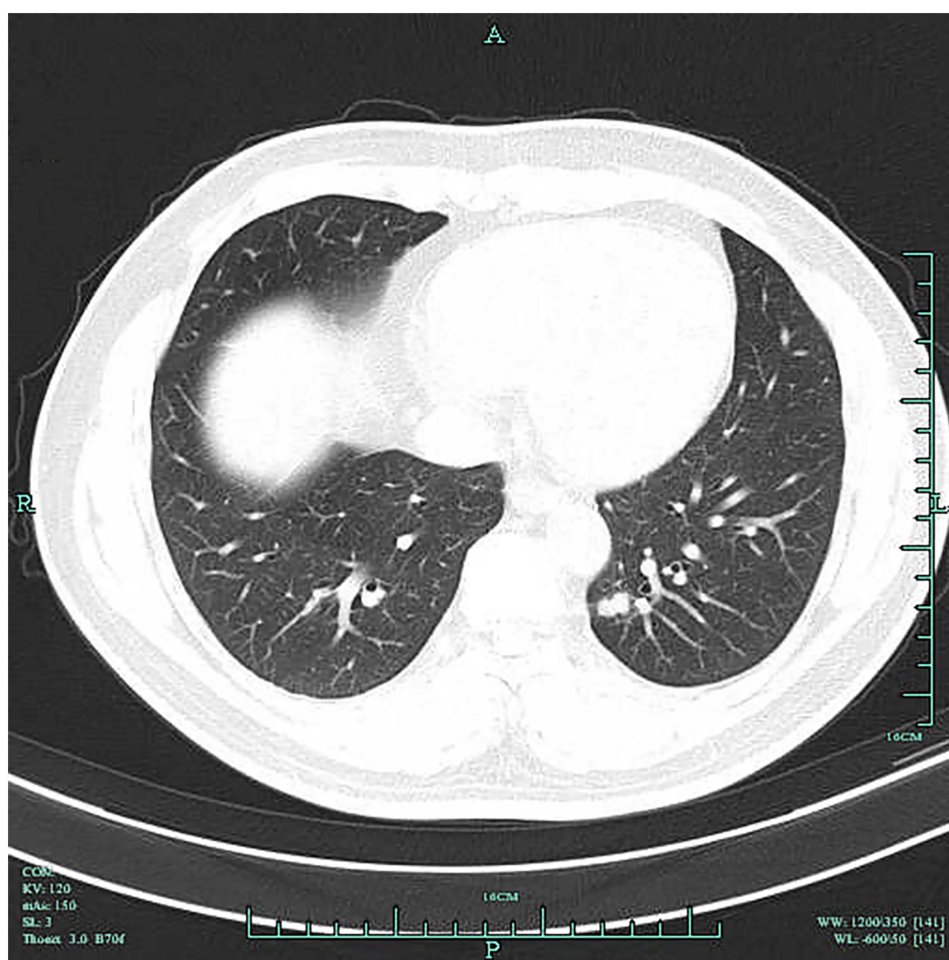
CT signs of low-dose spiral CT in patients with benign lesions.
